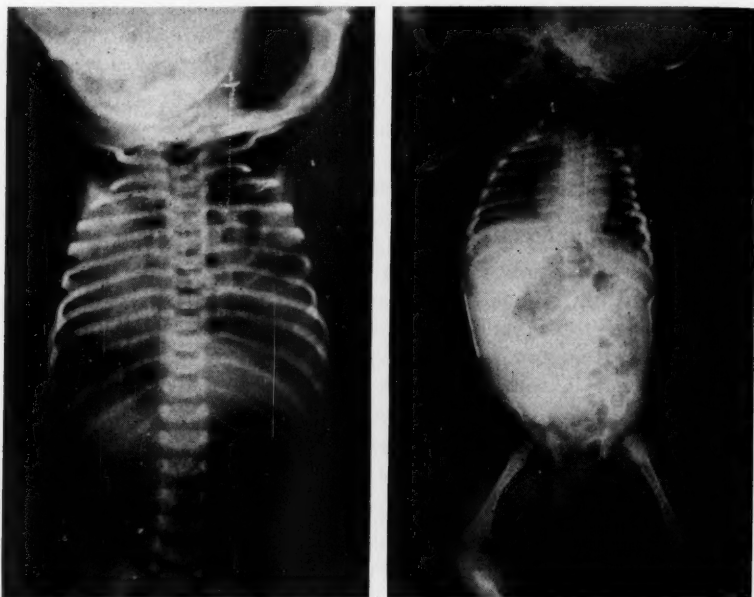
X-ray of infant immediately after admission to the hospital showing the gas and fluid containing loops of bowel extending to the dome of the left pleural space. Note the marked displacement of the heart to the right side, further decreasing the lung area for respiratory exchange to a critical level. The shadow within the abdomen represents dilated stomach.
